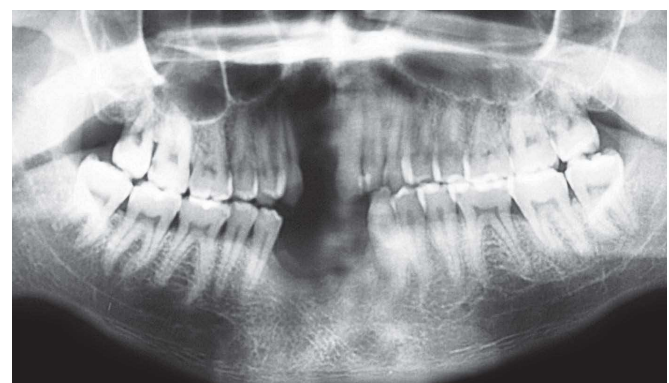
Initial radiograph of the case.
